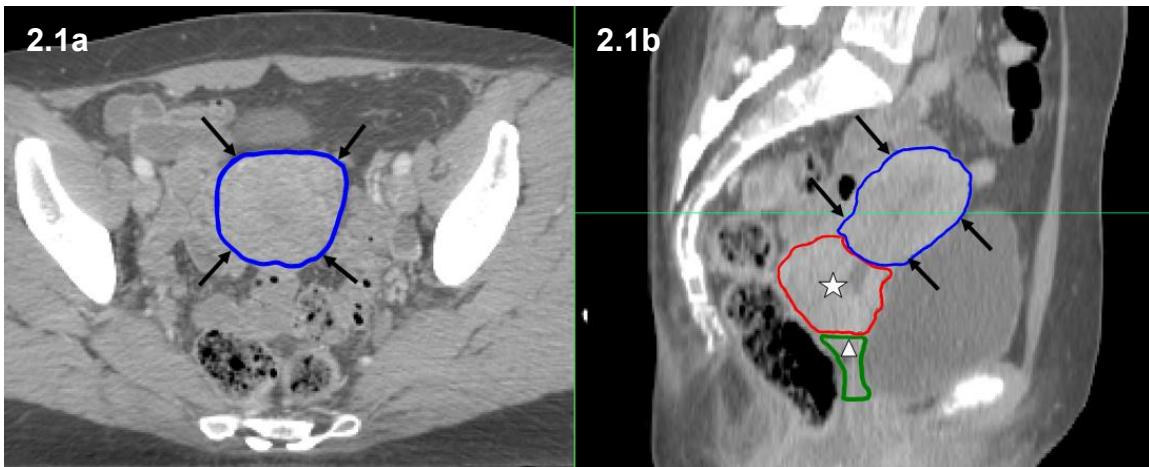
Axial (a) and sagittal (b) CT with the uterine corpus (blue), uterine cervix (star) and vagina (triangle)
